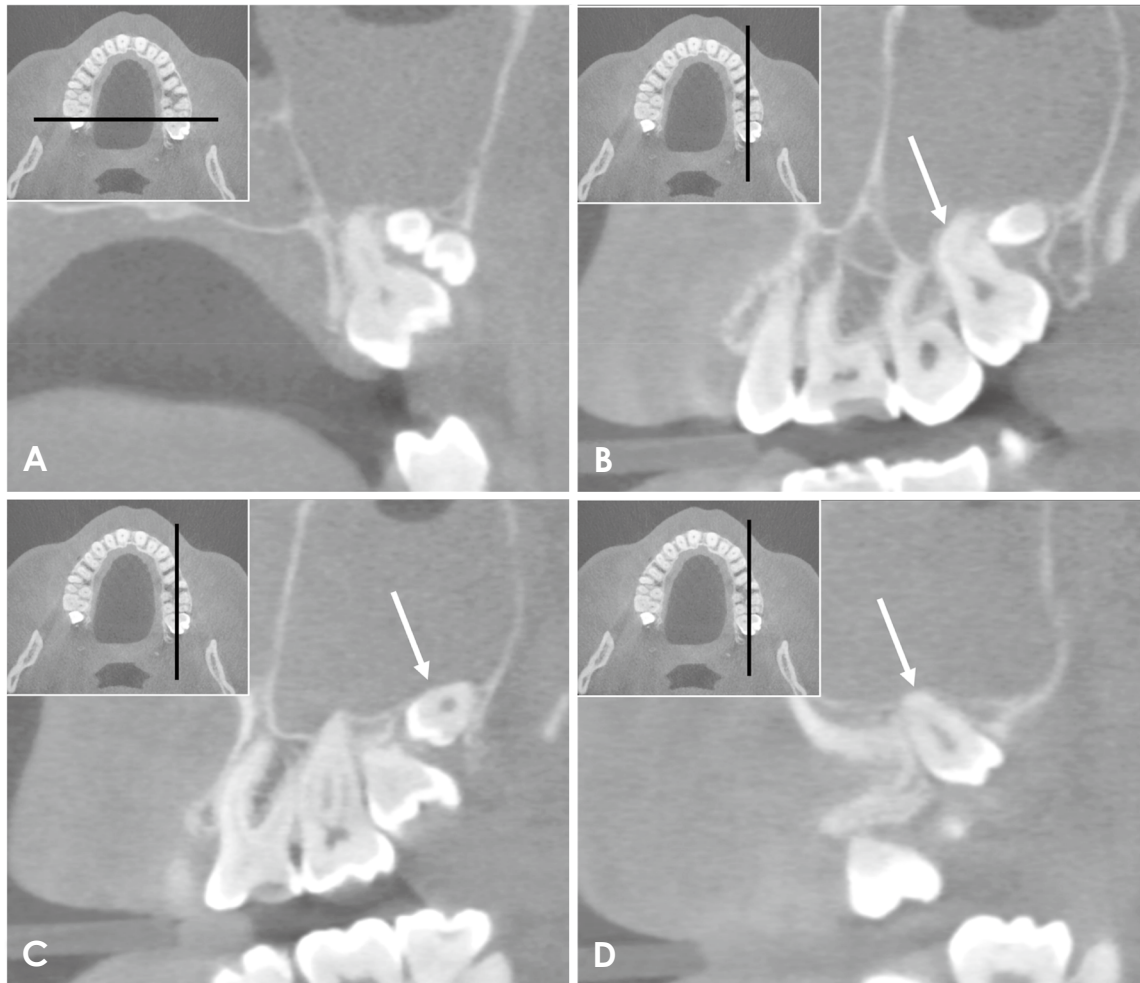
A. Coronal reconstruction of the patient's cone-beam computed tomography shows the maxillary third, fourth and fifth molars in the left maxillary quadrant. Sagittal reconstruction images show the maxillary third (B), fourth (C), and fifth (D) molars in the left maxillary quadrant.
